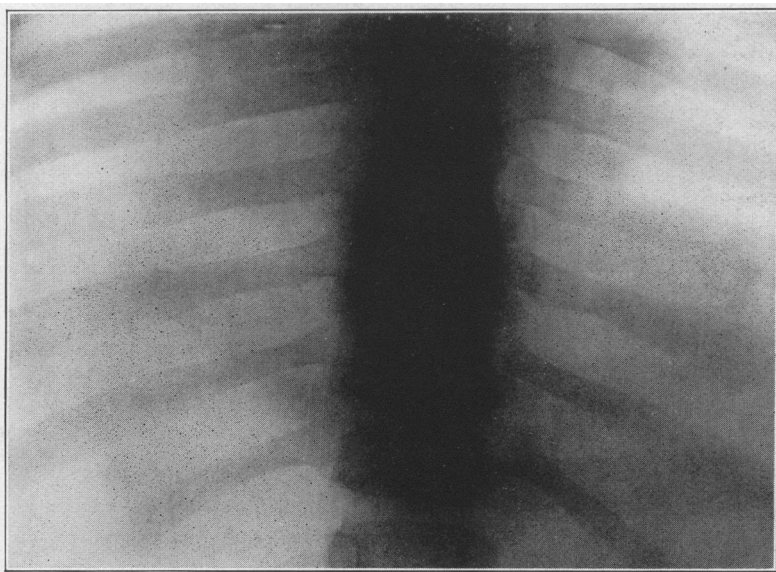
Same case. On a recurrence of the symptoms, this radiograph was taken, showing the presence of a coin which was prevented by spasm from entering the stomach. It was removed with the aid of the esophagoscope.
